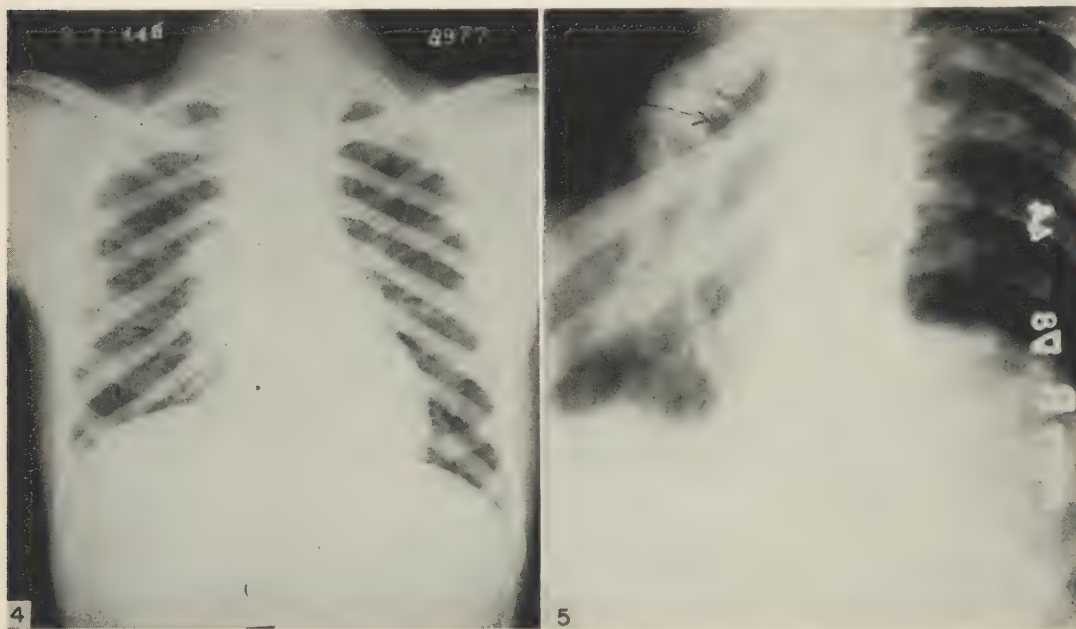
Endogenous reinfection pulmonary coccidioidomycosis, AIP Ac. 150192: Roentgenogram of bilateral widespread diffuse and focal consolidation of the bronchopneumonia type, accompanied by bronchial and mediastinal lymphadenitis. Death on 274th day with widespread dissemination of lesions. Gross appearance of lung not unlike that shown in Figs. 6 and 7.
